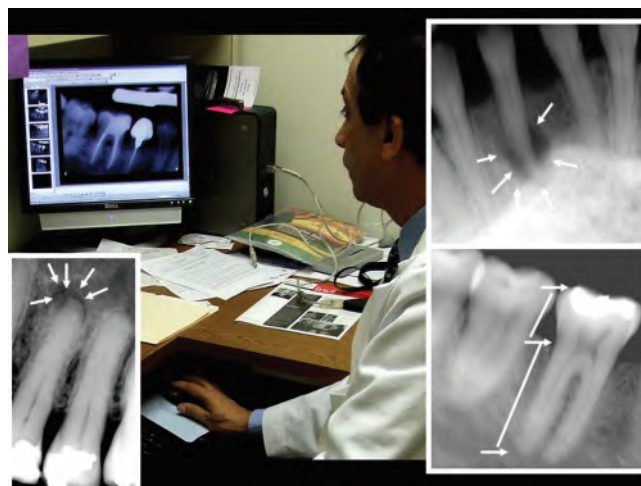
9 Endodontic evaluations using the Kodak RVG-6000 (Kodak Dental Imaging, Marne-la-Vallée, France) CMOS system. These details clearly demonstrate the ability of solid-state sensors to demonstrate periapical lesions and tooth length (even with long root length in rhizodontia).
